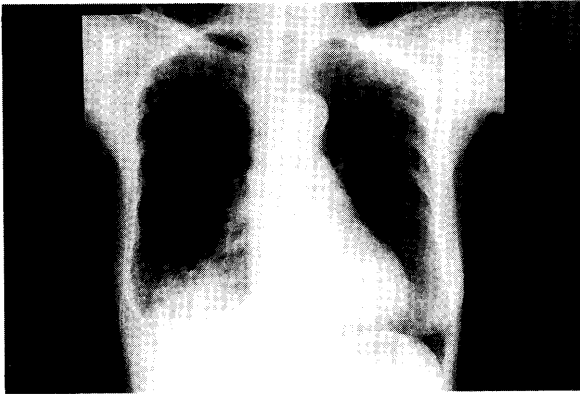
A chest radiograph shows infiltration of the right lower lobe.
